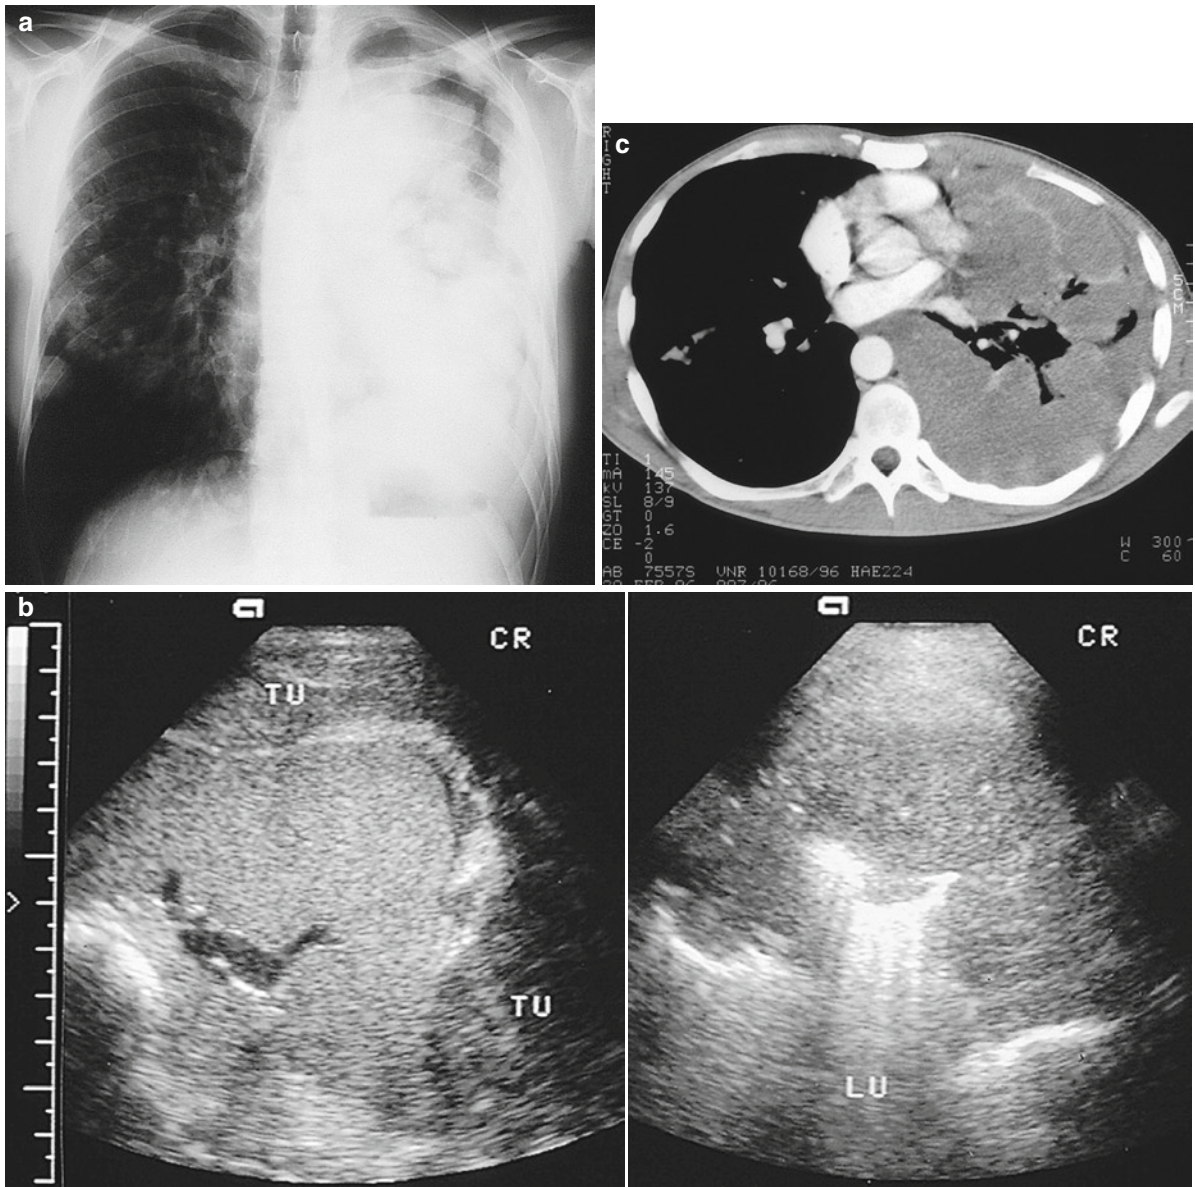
A 64-year-old man with bronchial carcinoma. (a) Chest radiograph. Complete opacity of the lung on the right side. (b) Ultrasonography. The lateral intercostal ultrasound beam
